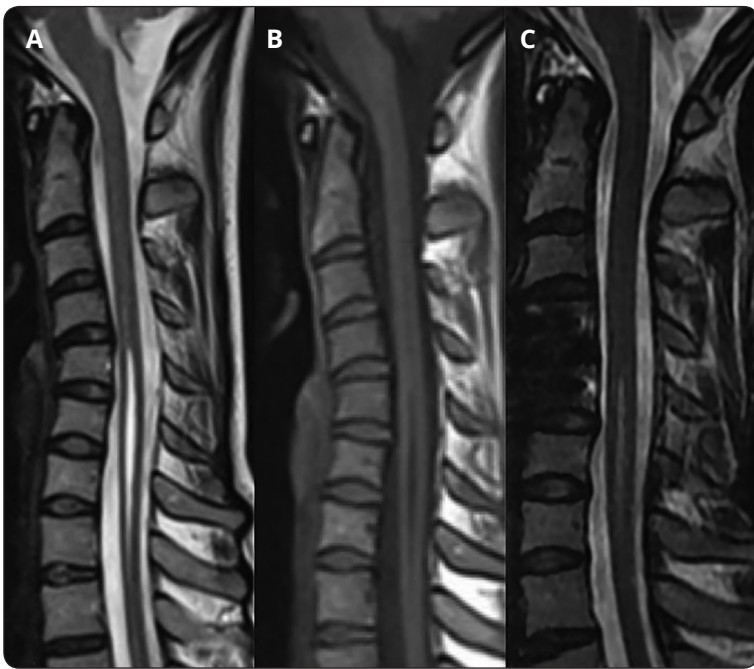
Case 10 T2 weighted A and B T2 weighted sagittal MRI of distal type Grade 2 syrinx and C4-C5 segmental kyphosis. T2 Weighted C MRI following C4-C5 microdiscectomy and anterior cervical plating shows resolution of syrinx
